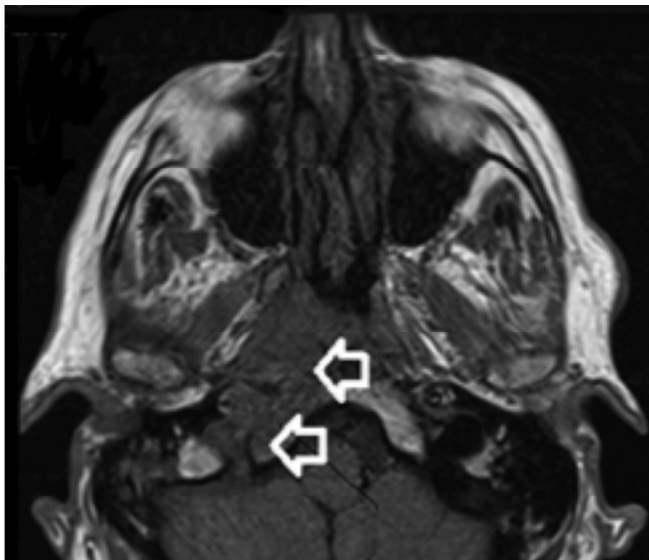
MRI: The abnormal signal extending along the petrous apex into the right side of the clivus and involving the right side of the nasopharynx (white arrows). Based on the above appearances, a biopsy from the right nasopharynx was suggested.
